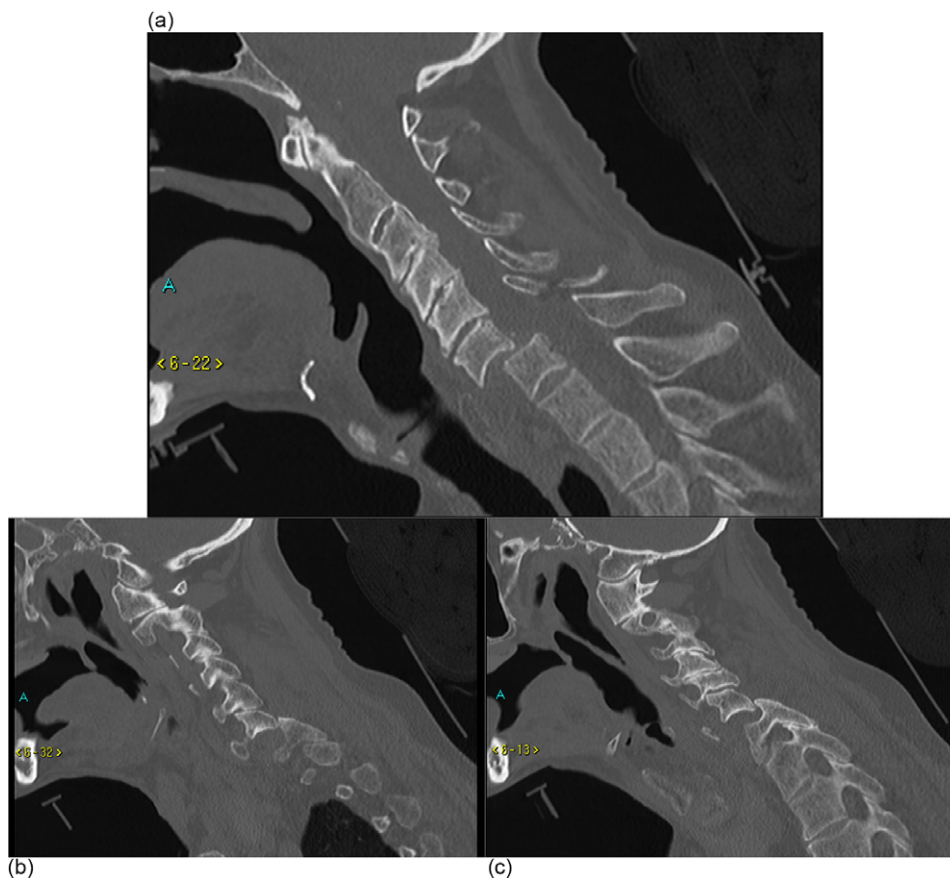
(a)–(c) Sagittal and parasagittal CT reconstructions
